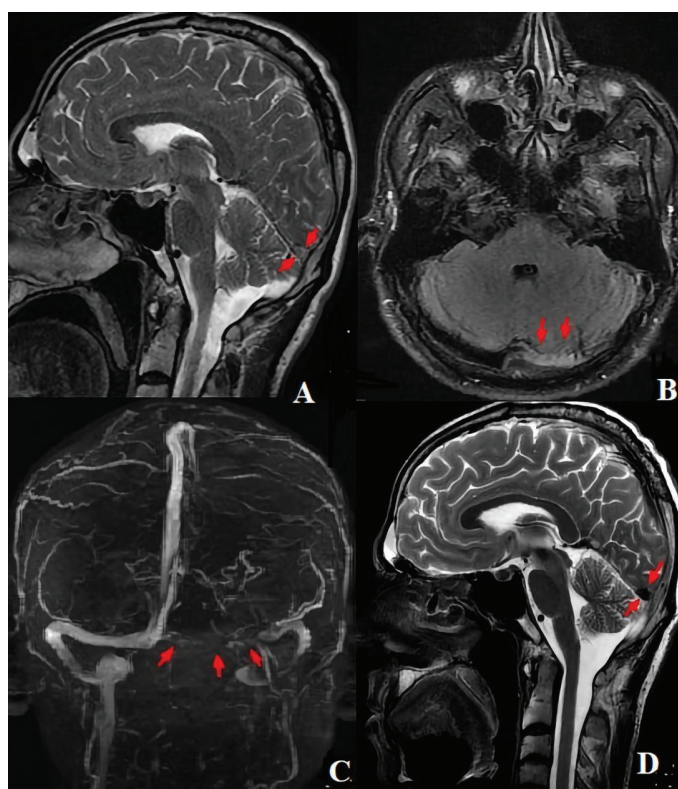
A) (red arrows) Abnormally high signal intensity sagittal T2-weighted. B) (red arrows) Absence of flow void in the medial part of the transverse sinus in axial fluid-attenuated inversion recovery. C) (red arrows) Loss of signal intensity in the medial two-thirds of left transverse sinus in the coronal maximum intensity projection view from noncontrast two-dimensional time-of-flight magnetic resonance venography. D) (red arrows) Disappearance of the high signal intensity on sagittal T2-W images after treatment
